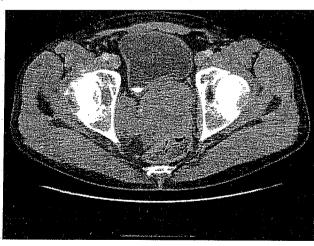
CT scan of the pelvis showing a mass emanating from the prostate to the right pelvic sidewall and compressing the rectum.
